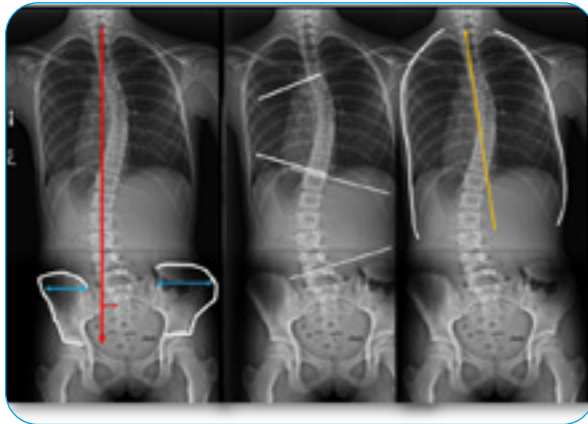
Frontal radiographs
